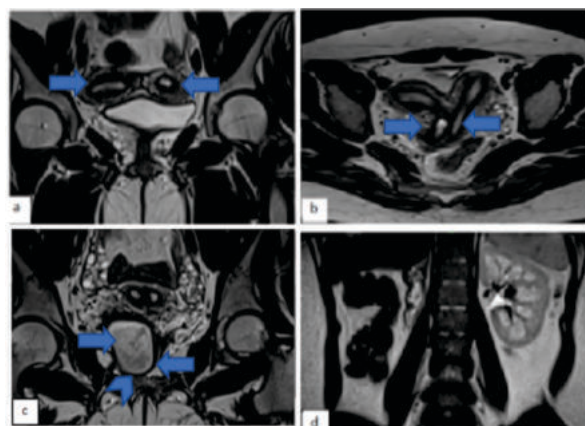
MRI findings; 1a - T2 coronal image showing two separate horns of the uterus depicted by two block arrows. 1b - T2 axial image showing two separate cervical canals depicted by two block arrows.
